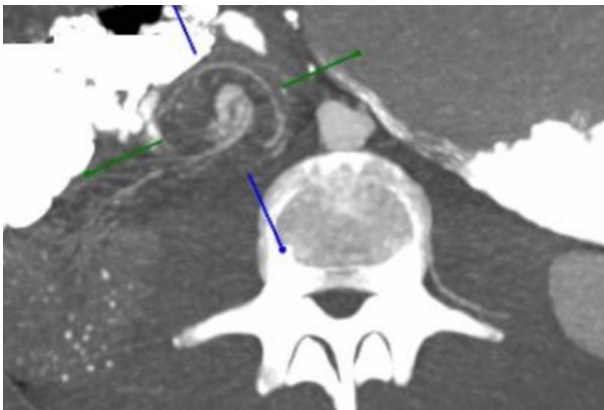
CT-scan axial section demonstrating a “whirl sign,” suggestive of intestinal volvulus.
